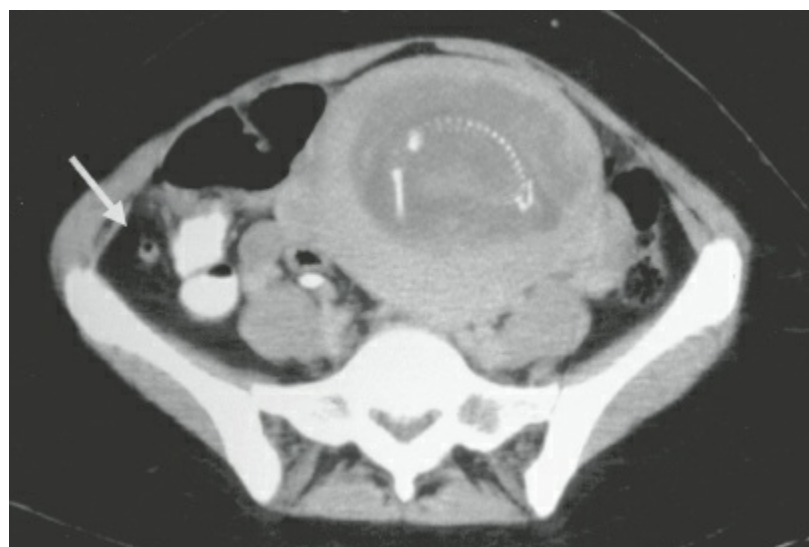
Computed tomographic (CT) scan of a woman in the 18th week of gestation presenting with a 12-hour history of right-sided abdominal pain. Abdominal examination on presentation revealed significant tenderness, and after a nondiagnostic ultrasonography, a laparotomy is considered for presumed appendicitis. A CT scan is obtained instead, revealing a normal, air filled appendix with no sign of periappendiceal inflammation (*arrow*). The laparotomy was postponed, and 12 hours later the patient aborted a septic fetus. An unnecessary laparotomy for an atypical presentation of chorioamnionitis was avoided by the judicious use of the CT scan. (Courtesy of Dr. David Weiss, Chestnut Hill Hospital, University of Pennsylvania Health System, Philadelphia, PA.)
